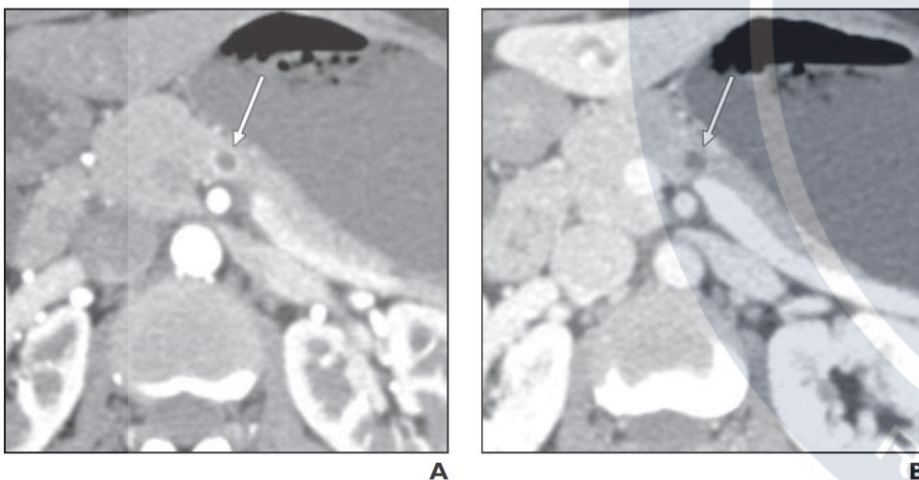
Well-differentiated neuroendocrine tumor (NET), nonfunctioning, in 47-year-old woman. Small cystic lesion was incidentally found on CT performed for evaluation of hematuria. Endoscopic ultrasound and fine-needle aspiration revealed pancreatic NET (case 6 in Table 2).
